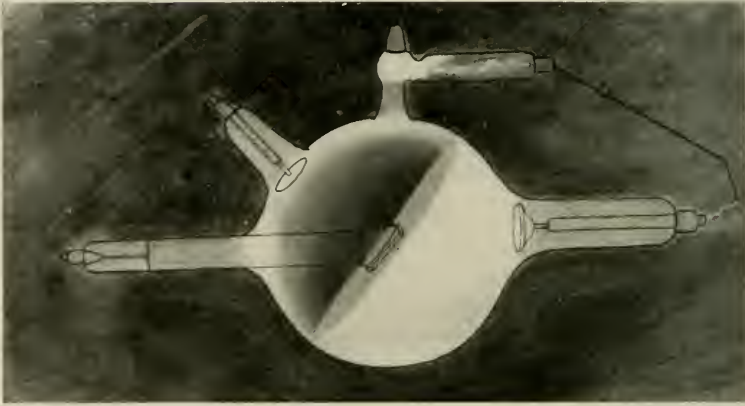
X-ray tube properly lit up.
